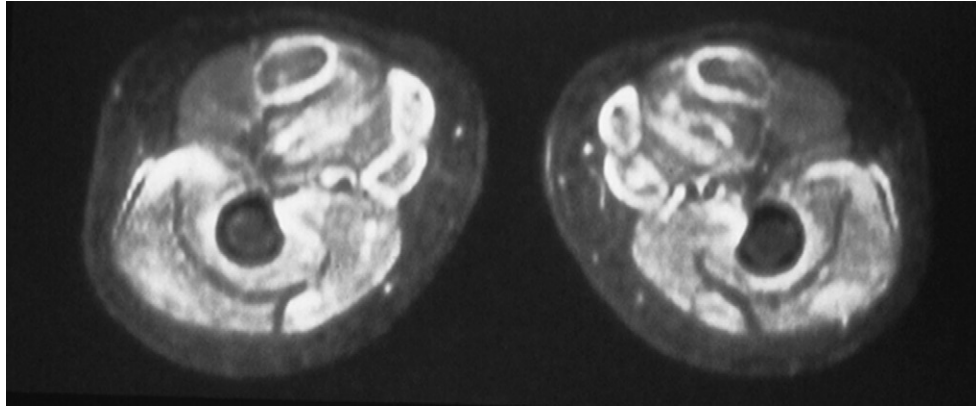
Magnetic resonance images (short tau inversion recovery) of the thigh. Note the symmetric inflammation in the affected muscle, seen as bright areas relative to unaffected muscle.
